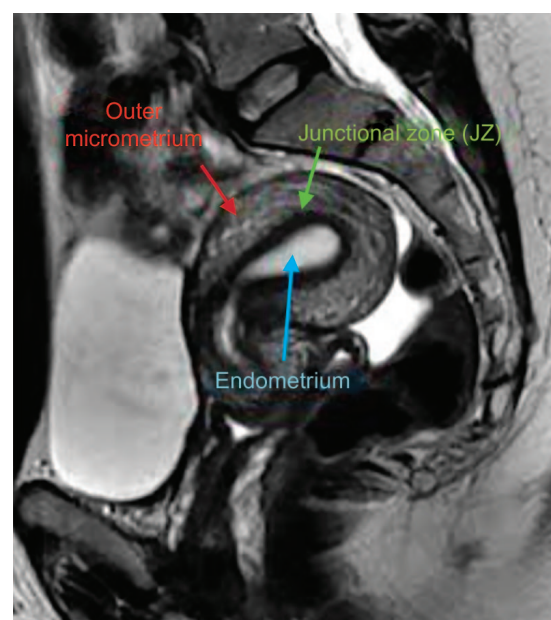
A sagittal T2-weighted MRI image of adenomyosis showing thickening of junctional zone
